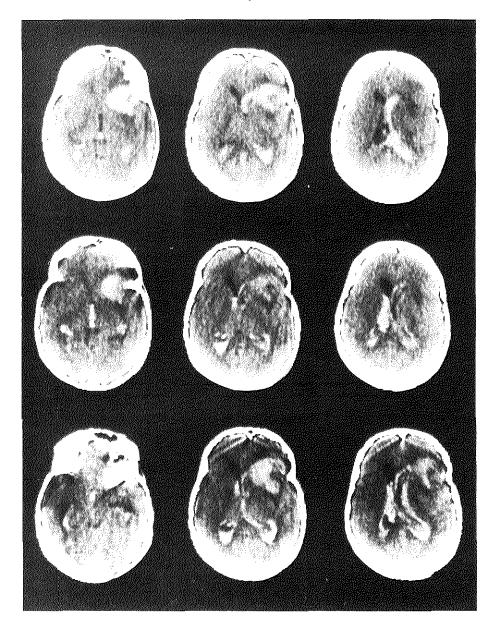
Three successive hemorrhages in one patient, clearly distinguished by serial CT scanning. Upper row (day 8): partial resorption of the initial hemorrhage (not shown), with a residual hematoma in the right frontal and temporal lobes (suggesting an aneurysm of the right middle cerebral artery), and in the right lateral ventricle and the posterior horn of the left lateral ventricle. Center row (day 12, after a sudden and transient loss of consciousness with fixed pupils): fresh blood is seen in the third ventricle and in the left lateral ventricle. Lower row (day 13, after another acute episode of impaired consciousness): the intracerebral hematoma is enlarged, and a rim of fresh blood in both lateral ventricles outlines the less dense clots of the two previous hemorrhages.
